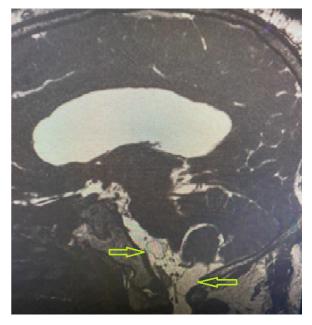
Sagittal MRI of the skull in the Fiesta sequence thin-walled vesicular lesions associated with racemose neurocysticercosis.
